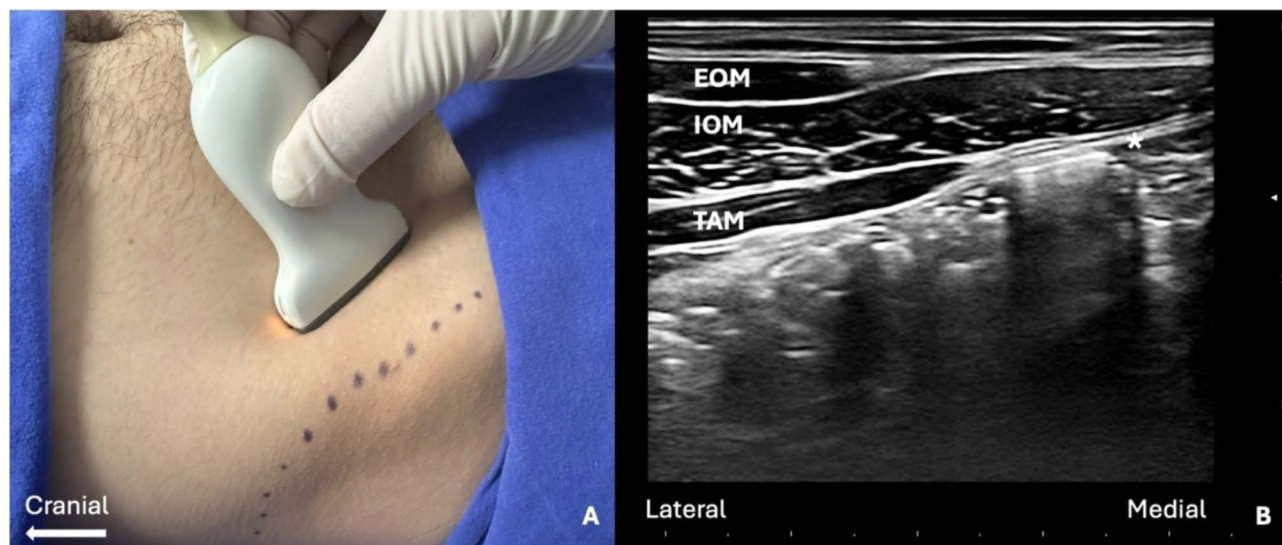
A: The probe position and B: ultrasound image when probe is advanced more medially while performing AIB to identify the muscle and fascia layers. EOM: external oblique muscle, IOM: internal oblique muscle, TAM: transversus abdominis muscle, *: aponeurosis of transversus abdominis muscle
